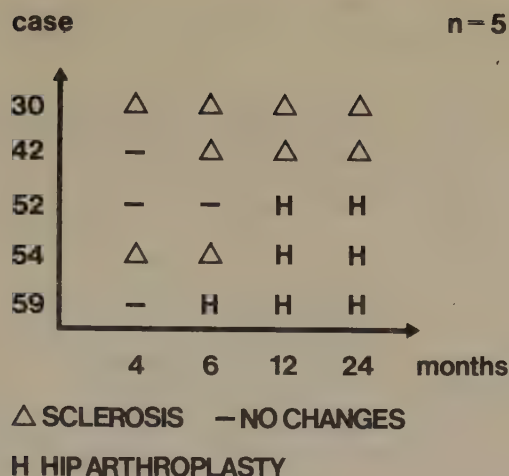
Radiographic changes in the femoral head of five femoral neck fractures with non-union.
